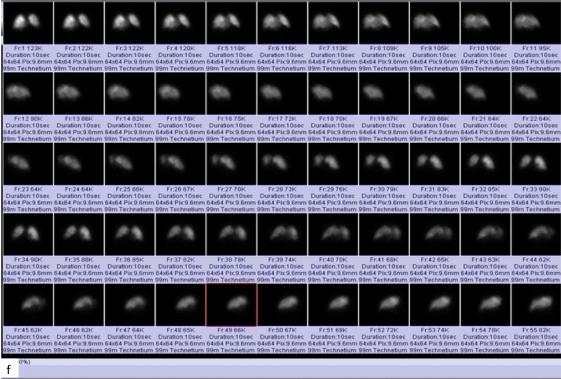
Comparison of CTA and V/Q scintigraphy of Patient 10. a: On axial plane examination of pulmonary angiography in the mediastinal window; Interruptions in the localization of the lower lobe basal segmental branches in both main pulmonary arteries secondary to chronic thromboembolism (a,b,c, arrows), hypodensity at this localization, decreased caliber and filling defect in distal segmental branches of the lower lobe (d, arrow). e: Sections in the parenchymal window at the axial plane of the same patient; Mosaic perfusion pattern in bilateral lung parenchyma and fibroatelectatic parenchymal changes (arrow) in the peripheral parenchyma of the lower lobe basal segments. f: V/Q scintigraphy showed mismatched defects in the right upper lobe apical, left superior-lingular, left lower lobe anterior.
